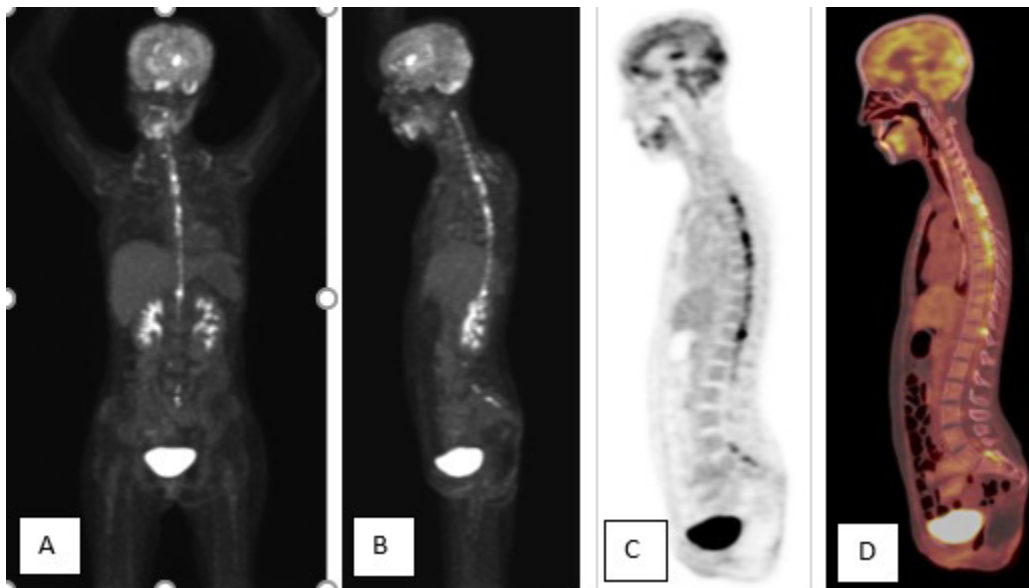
Maximum intensity projection images MIP(A&B), PET sagittal (C), and fused PET/CT sagittal (D) of 18F FDG PET/CT scan showing multiple heterogeneous and intense FDG uptake noted along the cervical-thoracic-lumbar-sacral spinal cord in keeping with ISCM.
